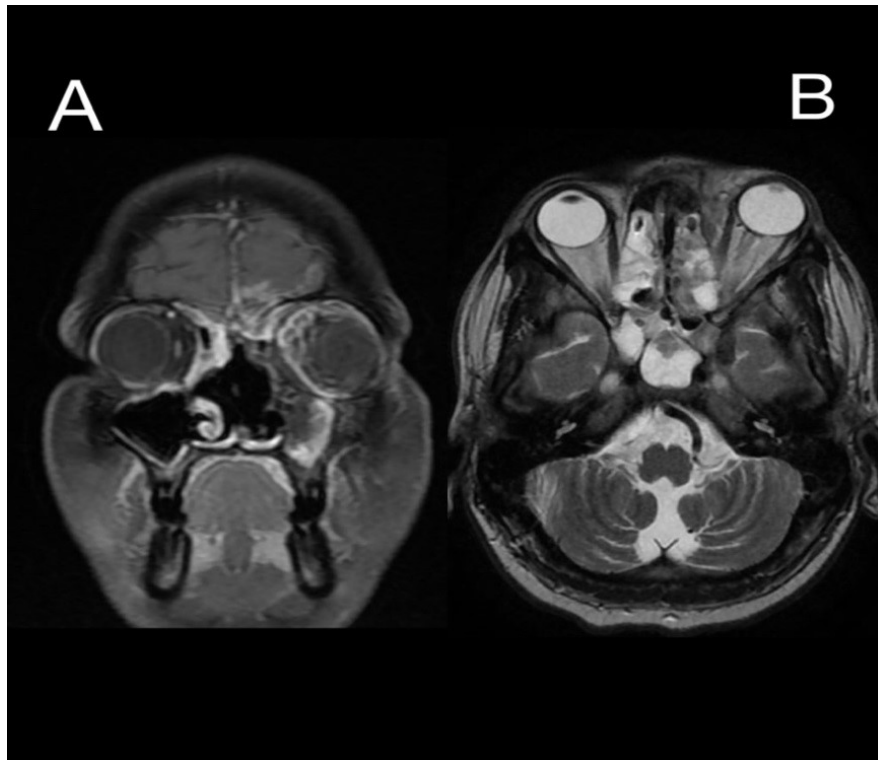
A- MRI image shows Axial T2WI image showing hyperintensity in the extraconal soft tissue in the medial aspect of the left orbit. B- MRI image shows coronal section T1WI post contrast shows enhancement of left extraconal soft tissue
